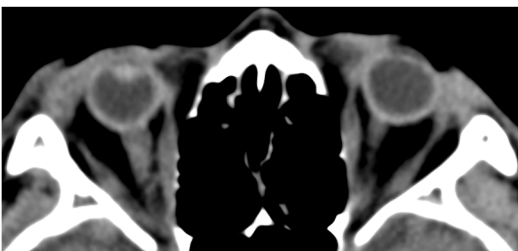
Unenhanced CT orbits demonstrates small volume globes which appear otherwise normal in configuration, consistent with microphthalmia.
